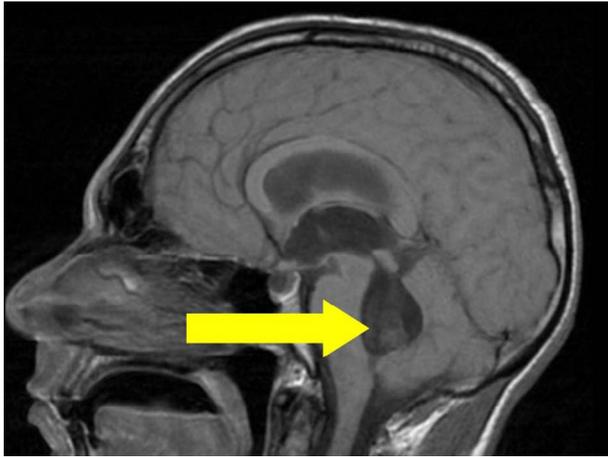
T1 MRI demonstrating a degenerating cyst adherent to the wall of the 4th ventricle.
